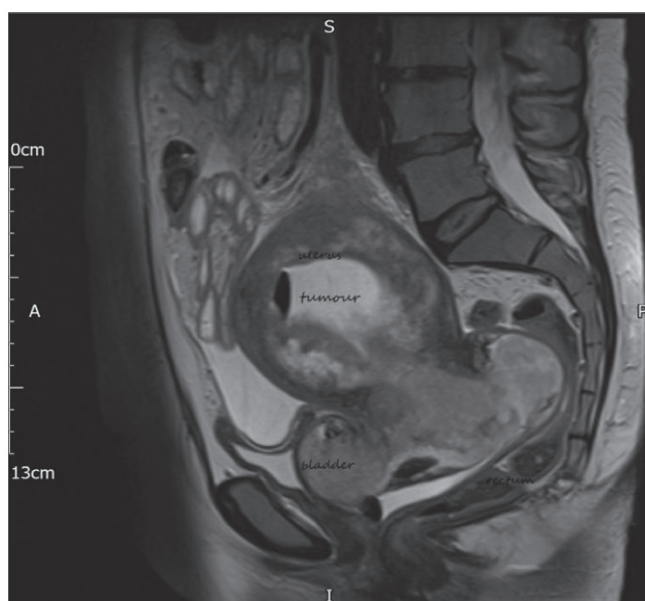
MRI scan demonstrating colo-endometrial fistula
